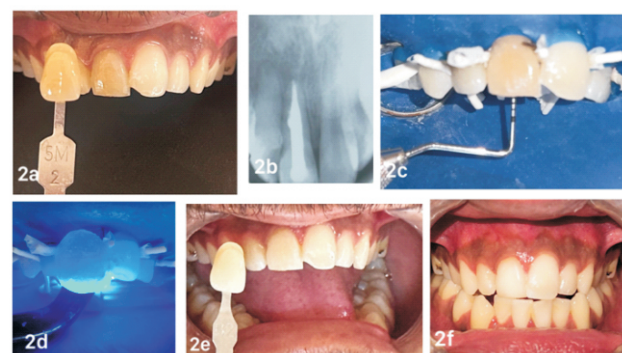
Non-vital internal bleaching of tooth #11 with sodium perborate + 5% H₂ O₂ using Lenhard-Serrano barrier design A) Pre-operative discoloration (Vita 3D 5M2) of root canal-treated tooth #11 B) Radiograph confirming adequate obturation and absence of periapical pathology C) Gutta-percha removal 2 mm below CEJ and placement of first GIC barrier 1 mm below the facial CEJ, parallel to gingival margin D) Insertion of sodium perborate + 5% hydrogen peroxide paste inside cavity and custom tray seated on tooth and light activation done followed by Cavit G placement E) Post-operative result showing shade improvement F) Three-month follow-up showing stable shade and healthy gingival margins
